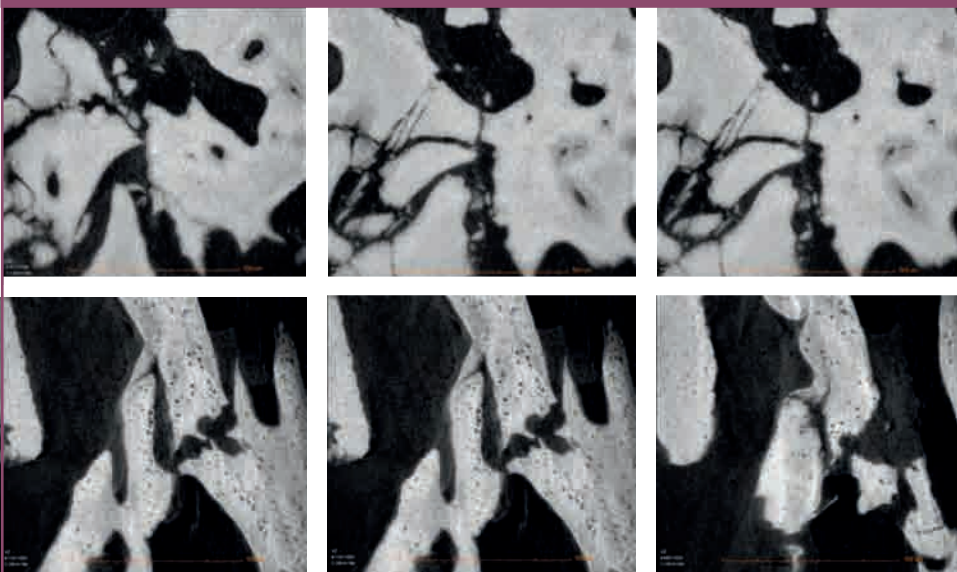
Images on the top rows are CT slices of bone sample retrieved from socket grafted with Xenograft showing a lack of new bone growth while images in the bottom row shows new bone regeneration through evidence of osteocytes, which the lighter regions shows compacted mineralized bones in the sample extracted from the socket preserved using Bioscaffold.
